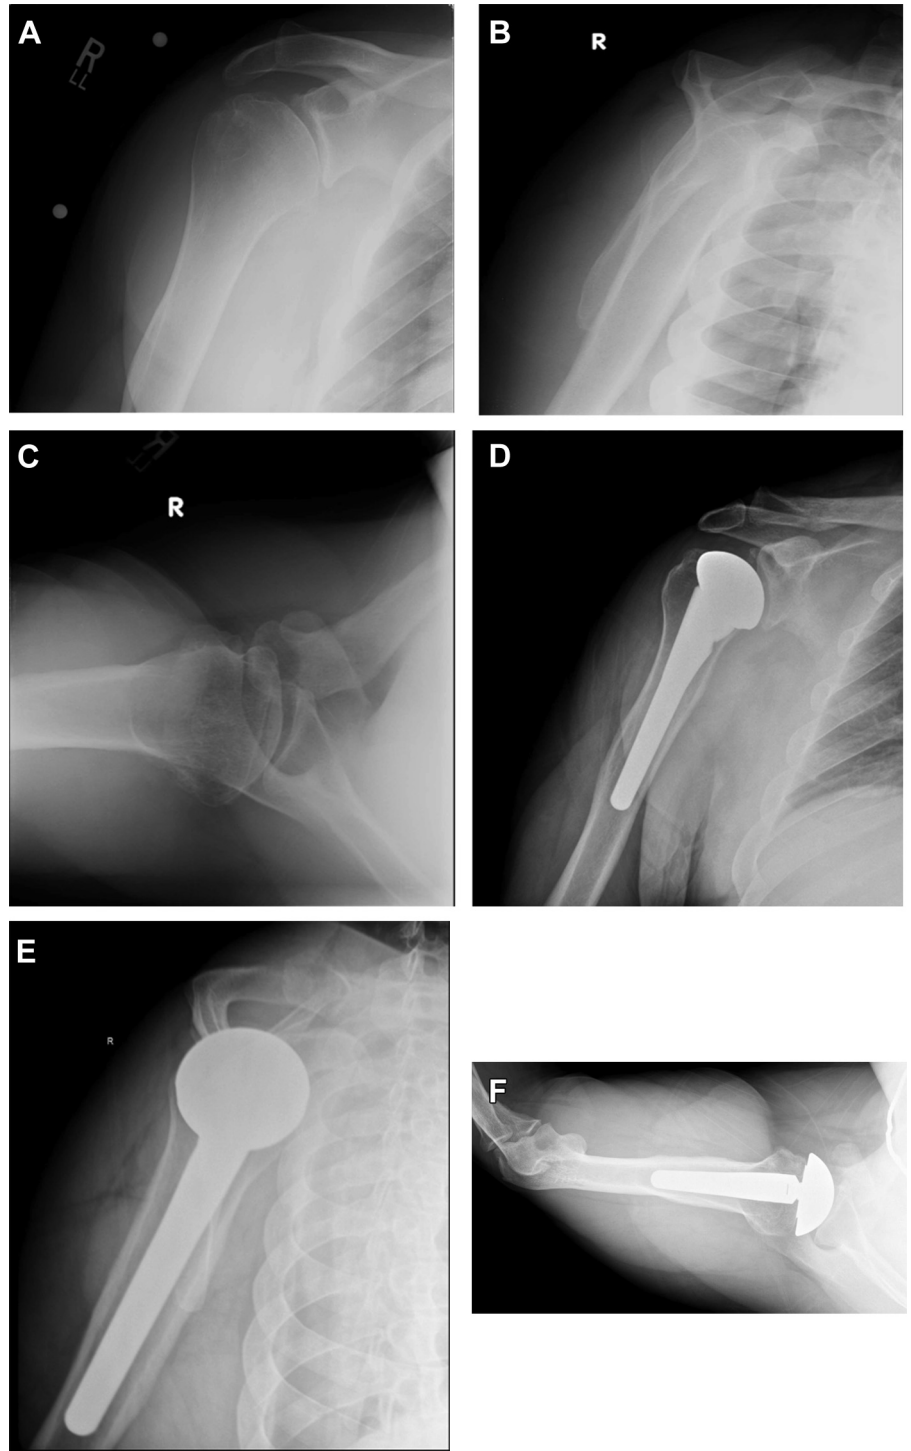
This 36-year-old man, who played high school and collegiate football, presented with progressive shoulder pain. Radiographs were obtained, including (A) Grashey anteroposterior (AP), (B) scapular Y lateral, and (C) axillary lateral views, which showed glenohumeral osteoarthritis. The patient underwent hemiarthroplasty, with subsequent resolution of his pain. Postoperative films at 1 year show a well-fixed and well-aligned prosthesis on (D) Grashey AP, (E) scapular Y lateral, and (F) axillary lateral views.
